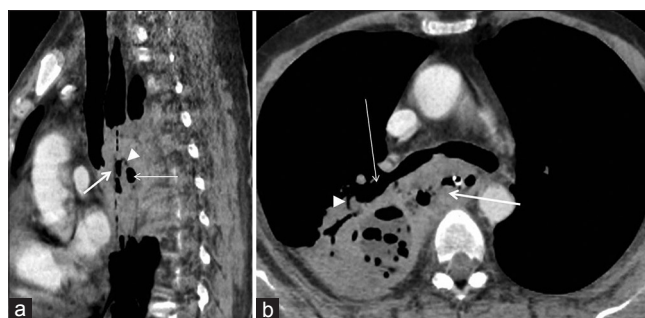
Sagittal (a) and axial (b) reformatted CT images in MinIP window showing definite communication (arrow head) between the mass (thick arrow) and right lower lobar bronchus (thin arrow)
